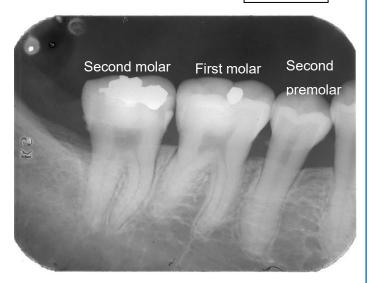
Intra-oral X-ray Images of the Patient's Mandible
